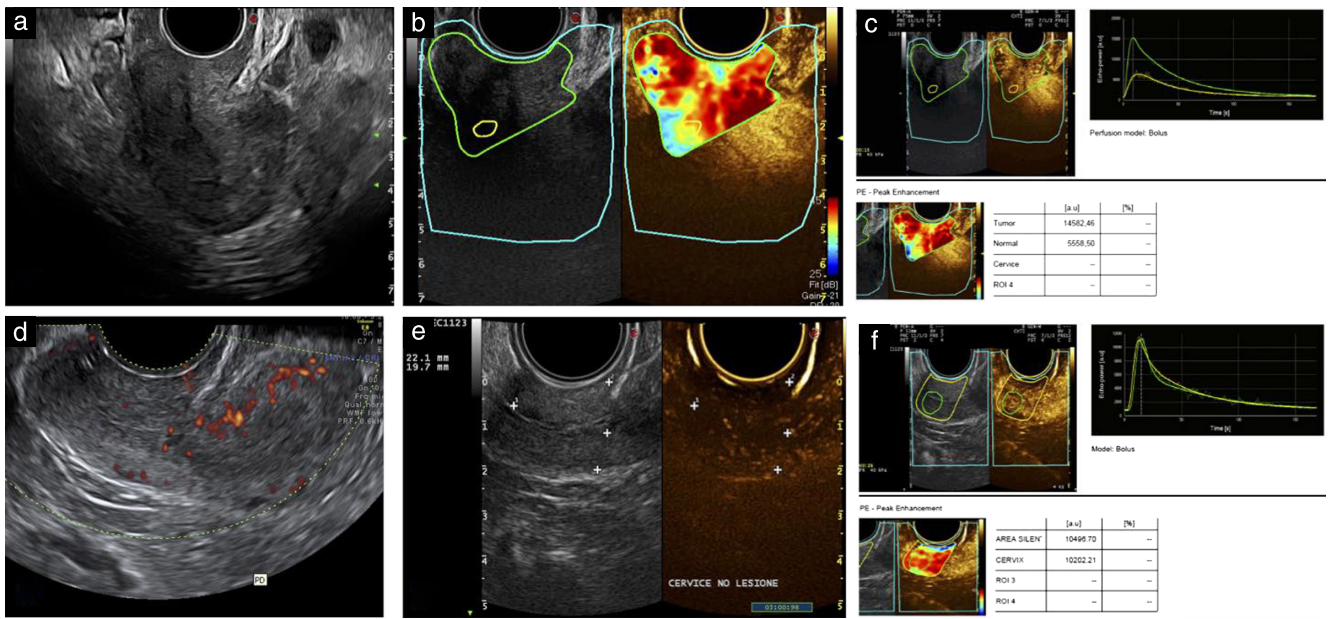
Images from two cases without visible lesion on ultrasound, one having pathological complete response (a–c) and the other pathological macroscopic residual disease (d–f), showing findings on power Doppler (a,d) and contrast-enhanced examination (b,c,e,f) of residual cervix.
